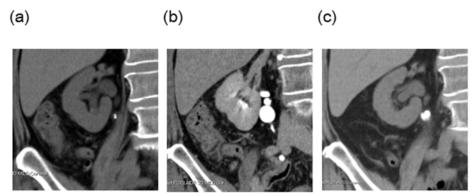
Non-contrast computed tomography (CT) (a) and CT urography (b) showed a ureteral diverticulum with stones inside. (c) Follow-up CT scan after eight months disclosed the enlargement of stone size.
